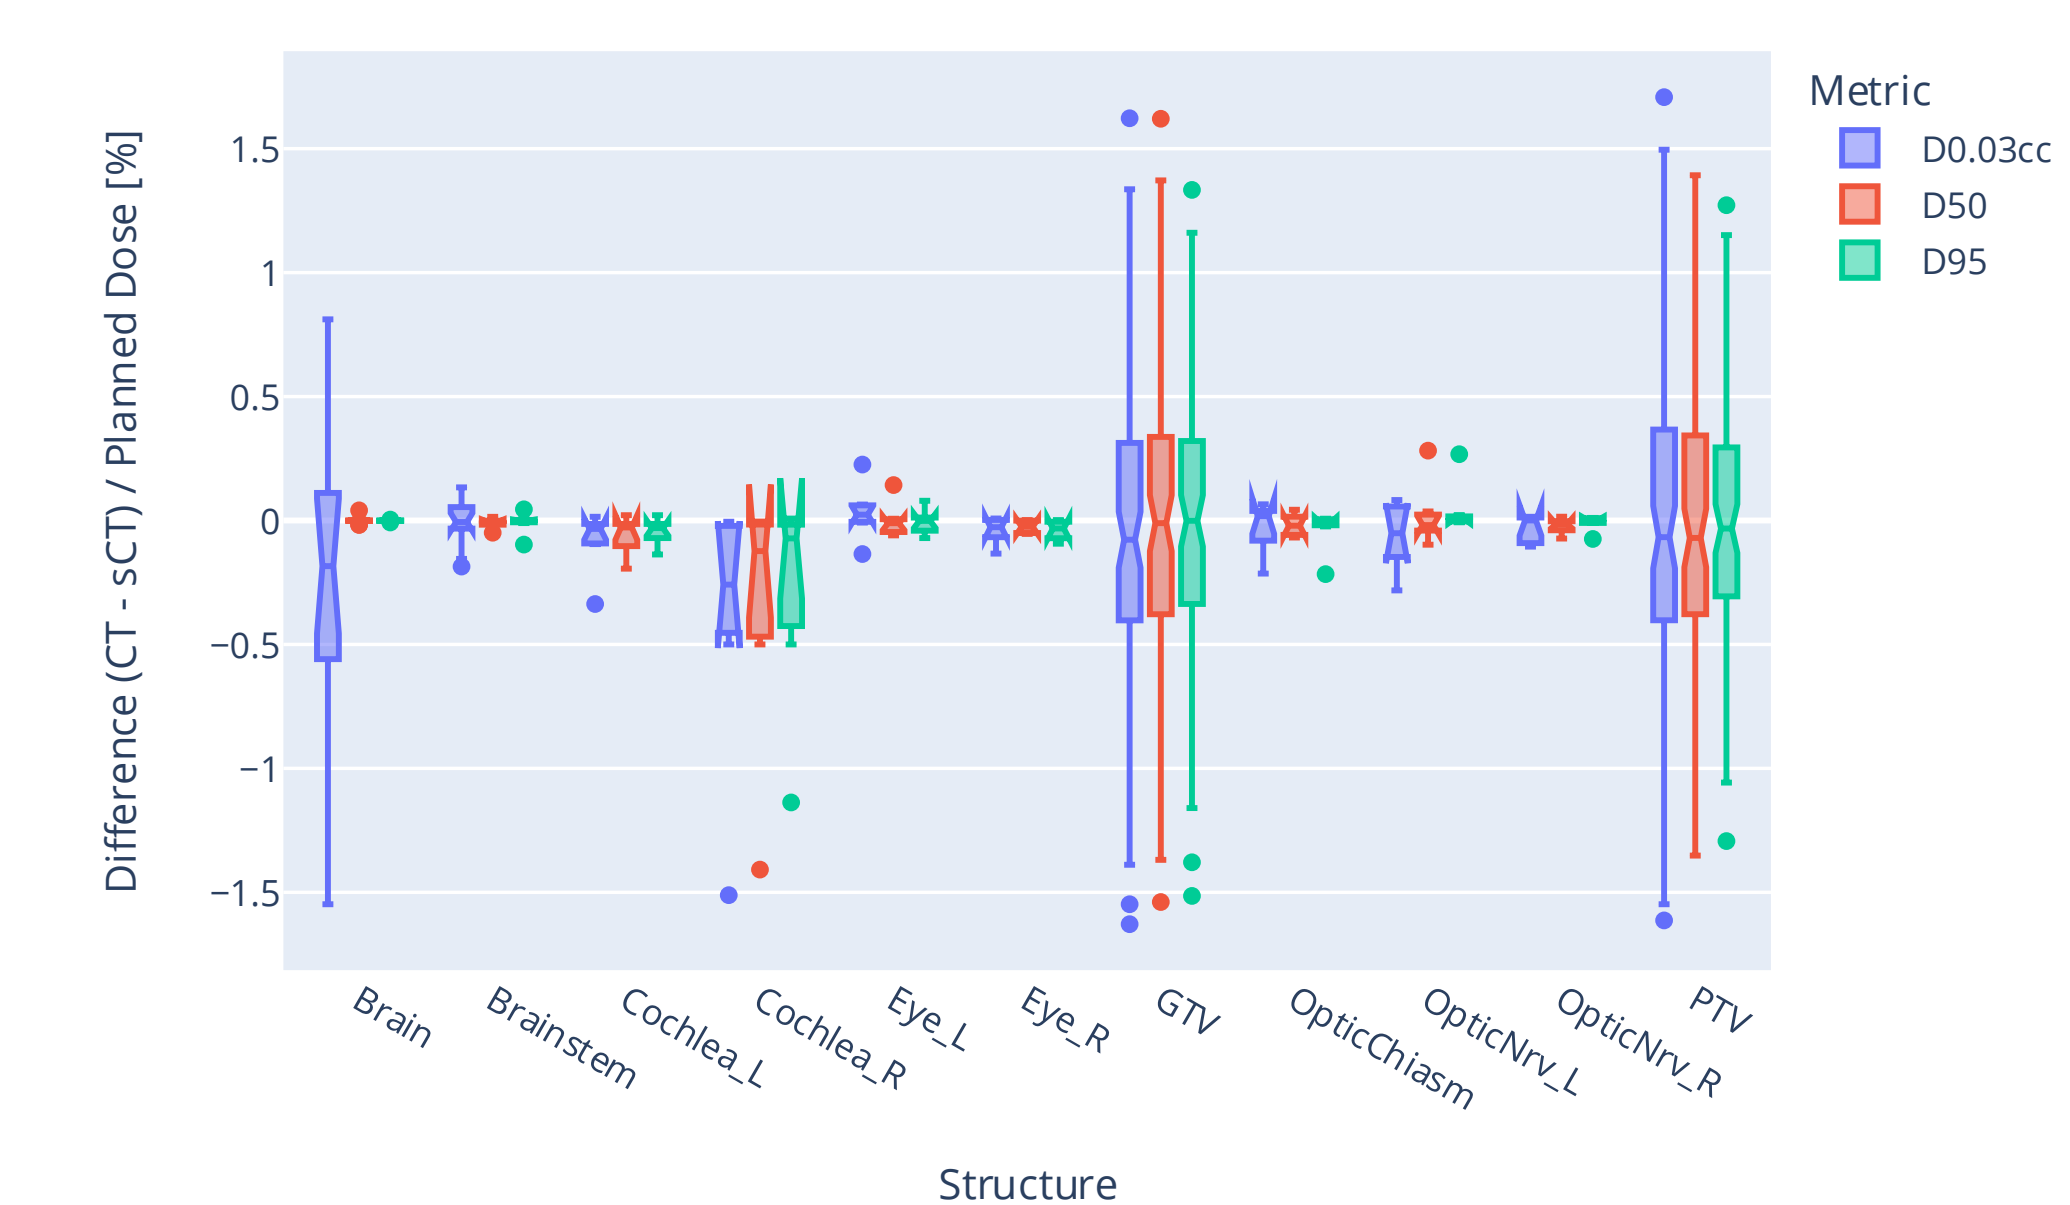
DVH dose statistics differences (sCT - CT) normalized by the planned dose across various target and organ-at-risk (OAR) structures. Data demonstrate minimal differences in absolute target coverage and OAR sparing.
